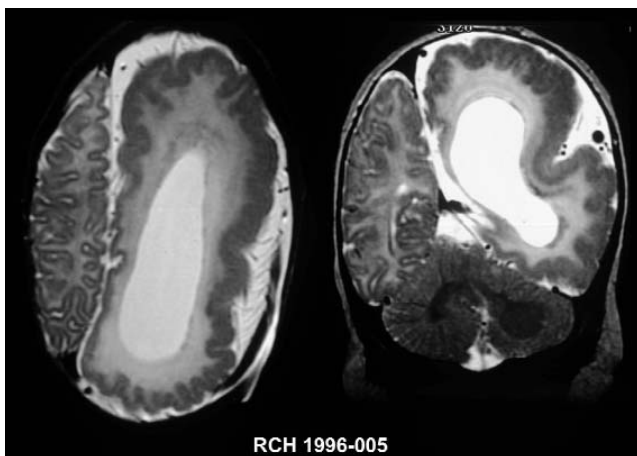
Imaging features of hemimegalencephaly. Axial T2-weighted MRI (left) and coronal T2-weighted MRI (right) of an infant with hemimegalencephaly showing an enlarged and dysplastic left hemisphere containing an enlarged lateral ventricle, periventricular heterotopic gray, excessive white matter, abnormal white matter signal, and gyral irregularity suggestive of polymicrogyria, all characteristic of hemimegalencephaly. MRI, magnetic resonance imaging
